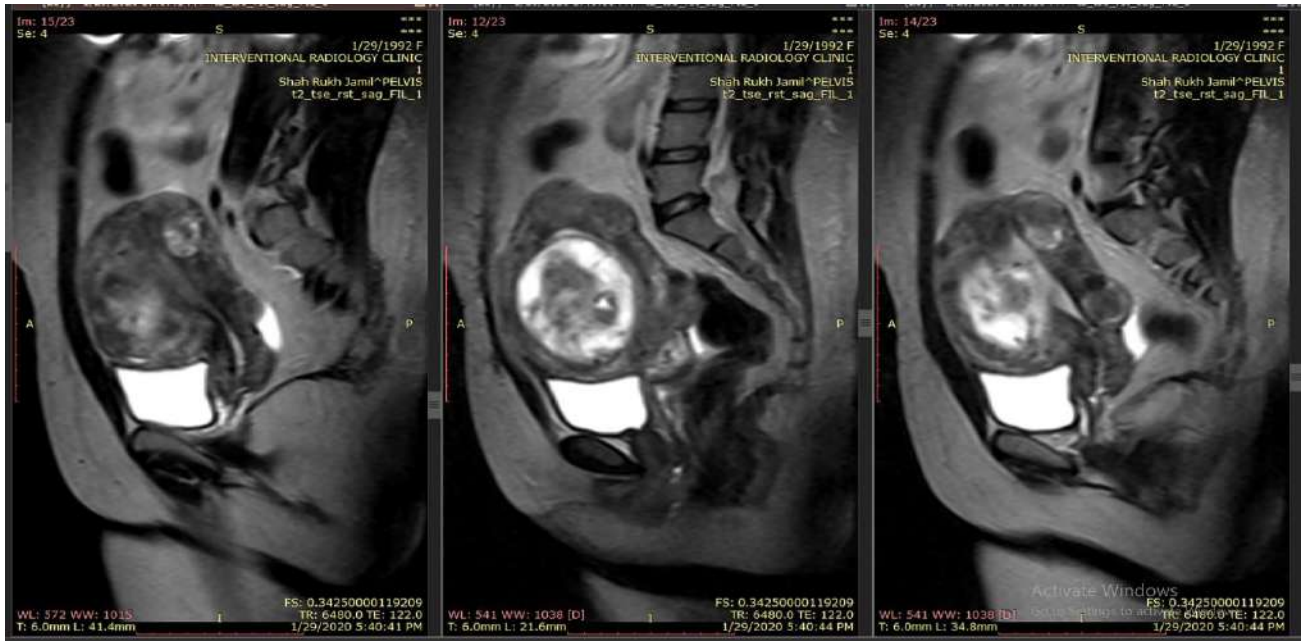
T2 sagittal MRI showing multiple variable size intramural fibroids giving heterogenous signals.
